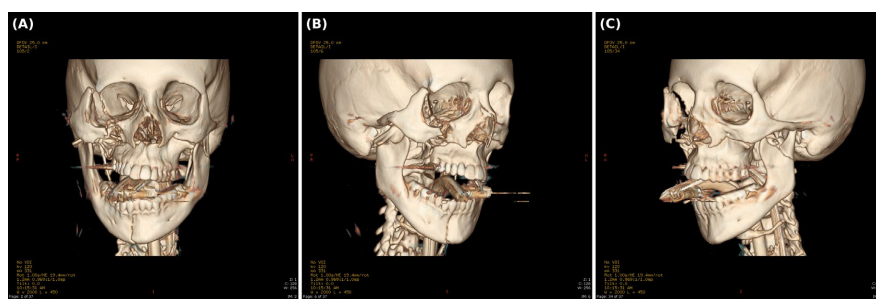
Preoperative three-dimensional computed tomographic reconstructions. (A) Frontal view showing panfacial disruption involving the mandibular symphysis, midface, and orbital buttresses. (B) Right oblique view showing zygomaticomaxillary-orbital displacement. (C) Left oblique view showing the contralateral midface and bilateral condylar/subcondylar injuries. Identifying information has been removed from all radiographic images.
